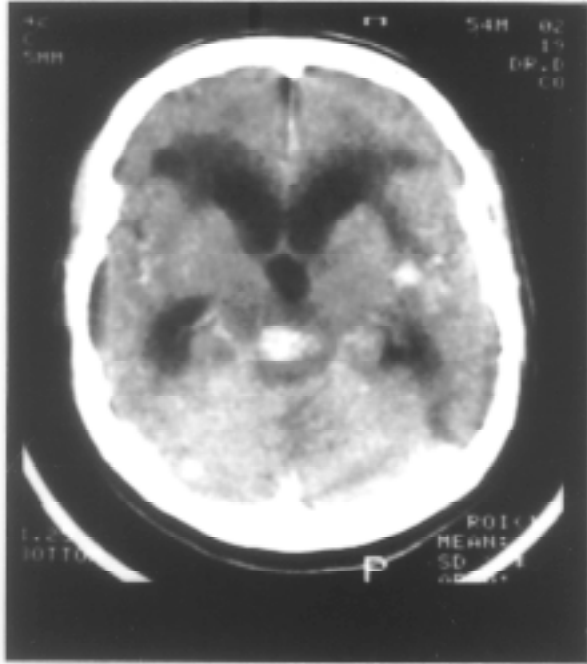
Contrast enhanced (CE) CT head showing basal meningitis, ventricular dilatation.
